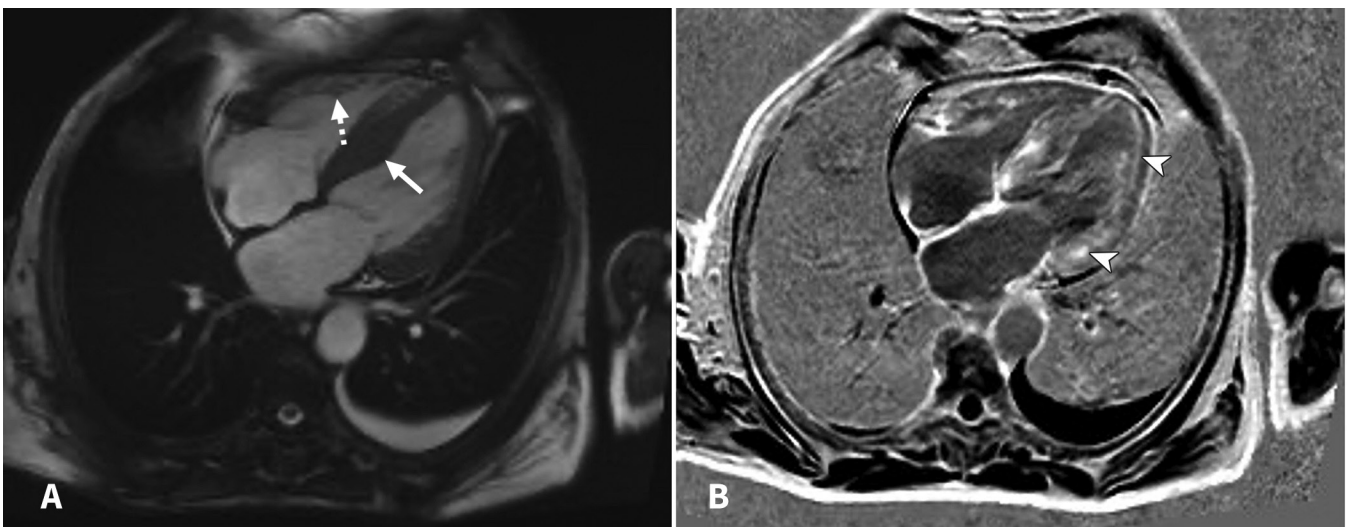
Cardiac magnetic resonance imaging (MRI) in a 65-year-old man with decompensated heart failure and neuropathy. The left ventricular outflow tract (4-chamber) steady state free precession cardiac MRI (A) shows left ventricular dilatation with asymmetric hypertrophy (solid arrow) and right ventricular hypertrophy (dashed arrow). The left ventricular outflow tract (4-chamber) delayed-enhancement cardiac MRI (B) shows diffuse delayed enhancement (arrowheads).
